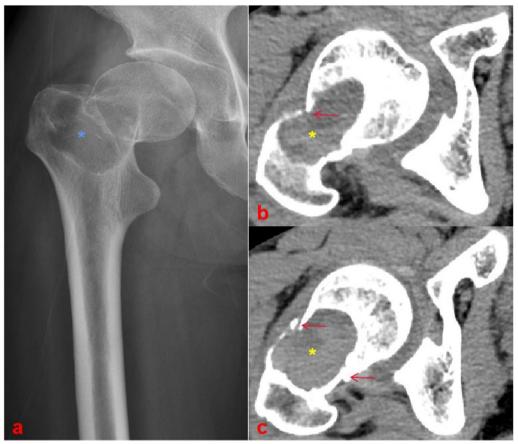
The radiographic images of the neck of the right femur in Patient 3. A Preoperative anteroposterior X-ray showed a typical ground-glass appearance (blue asterisk) and pathological bone fractures of the neck of the right femur. B and C Preoperative computed tomography image showing pathological bone fractures (red arrows) and cystic lesion of the site (yellow asterisks)
